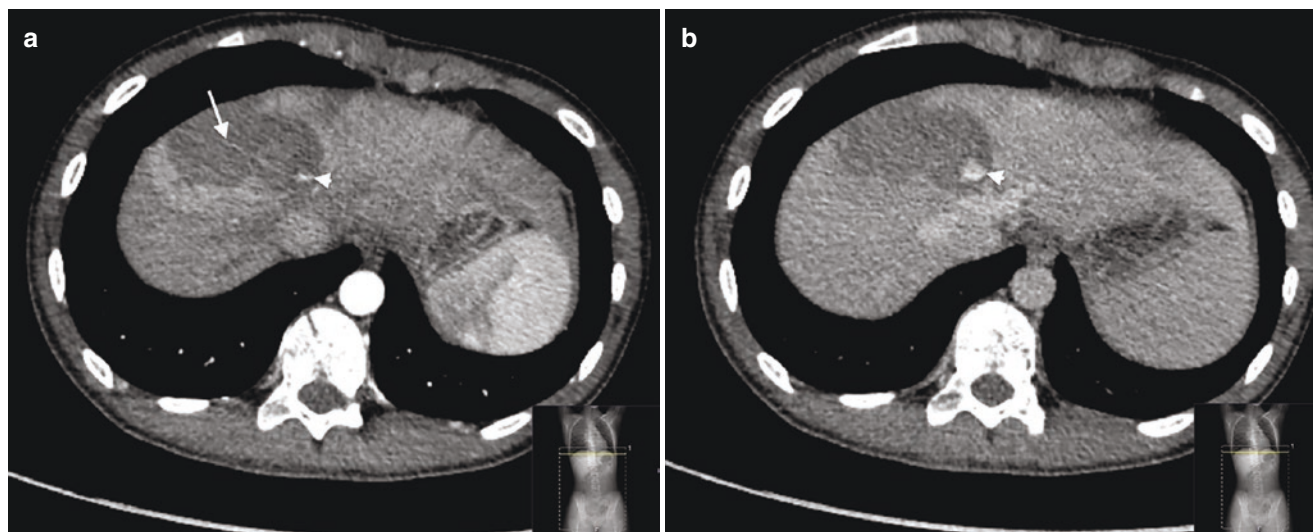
A dual-phase CT scan performed on patient following major trauma shows a large liver contusion (arrow, a) and active bleeding. (a) Extraluminal blush of contrast-enhanced blood in the arterial
